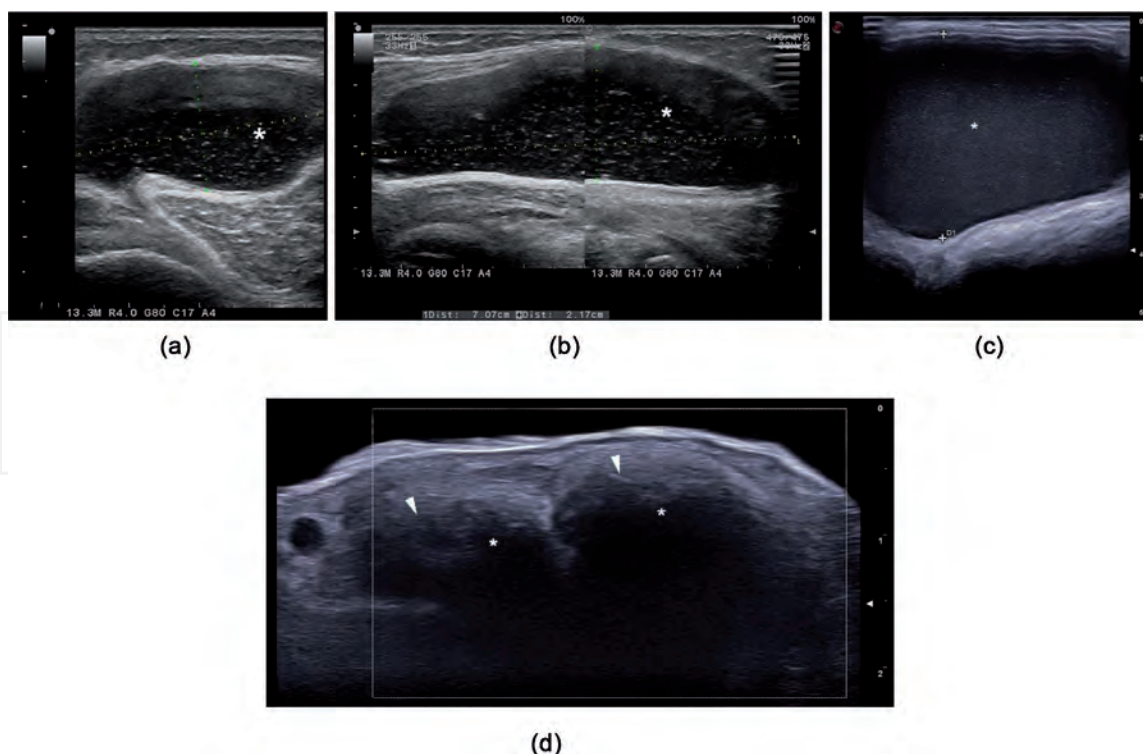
a–c. Ultrasound images of gouty synovial effusion at the level of the posterior knee – Popliteal cyst (a - transverse, b - longitudinal) and of the olecranon bursa, with the aspect of the “snowstorm” (anechoic area with hyperechoic spots). d. Gouty tophus (arrowhead), with posterior acoustic shadowing (asterisk).
